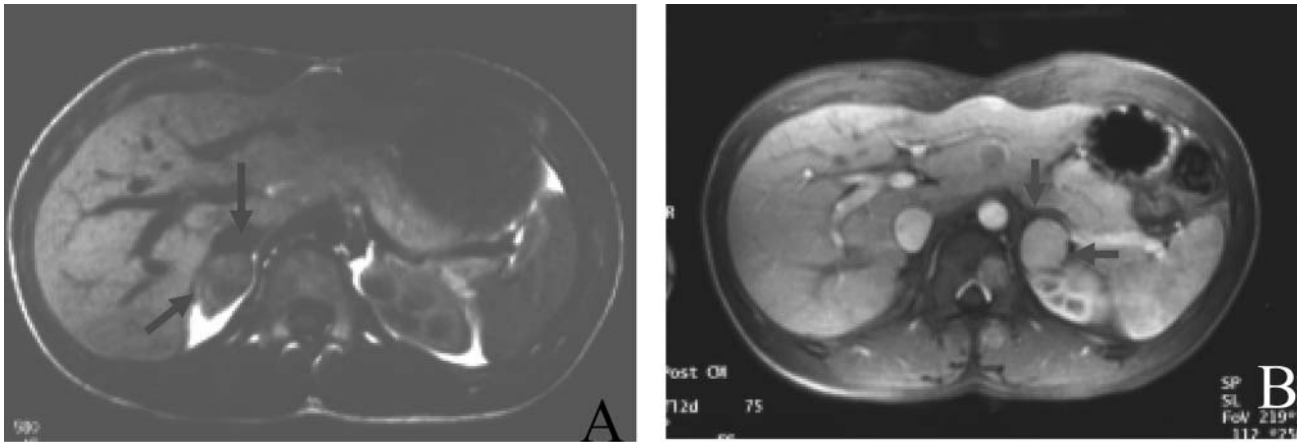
A: CT scan of abdomen in 1996 showing the right adrenal tumor. B: MRI of abdomen in 2002 showing the left adrenal tumor.
